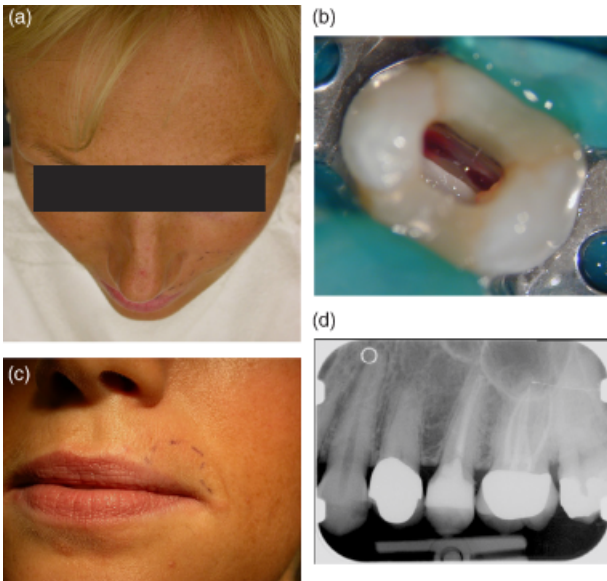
(a) Apical extrusion of 5% NaOCl during irrigation of tooth 25 resulted in immediate pain and hemorrhage. Swelling of the upper lip and left cheek developed as well as paresthesia. (b) Profuse bleeding from the root canals. (c) Symptoms resolved after 4 weeks; only slight paresthesia in the dotted region remained. Root canal treatment could be completed. (d) Radiograph following obturation of tooth 25. Case courtesy of Dr. Hager.
